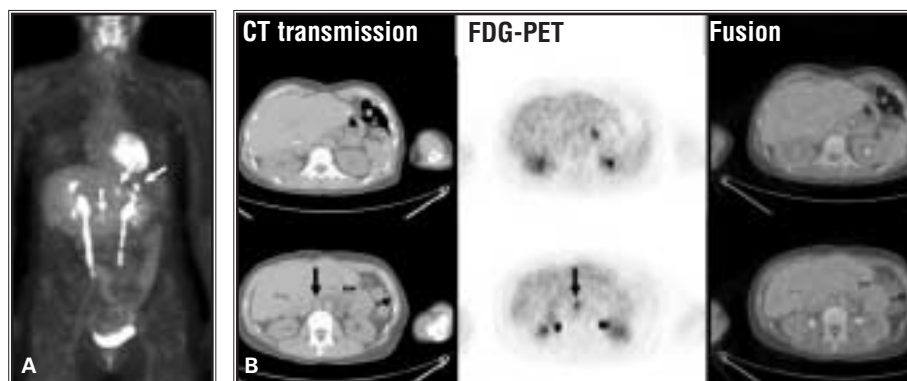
A 37-year-old woman with a history of colorectal carcinoma underwent a right hepatic lobectomy for hepatic metastases and presented with rising serum CEA levels. FDG-PET imaging was performed for detection of the site of recurrence and restaging. A: FDG-PET MIP image demonstrates physiologic FDG uptake in the myocardium, kidneys, ureters, and bladder. In addition, three foci of FDG uptake can be identified in the upper abdomen (arrows). B: Transaxial views through the foci of FDG uptake in the abdomen demonstrate that these foci of uptake correspond to mesenteric metastases (arrows). These metastases were detected only retrospectively on the CT images.
